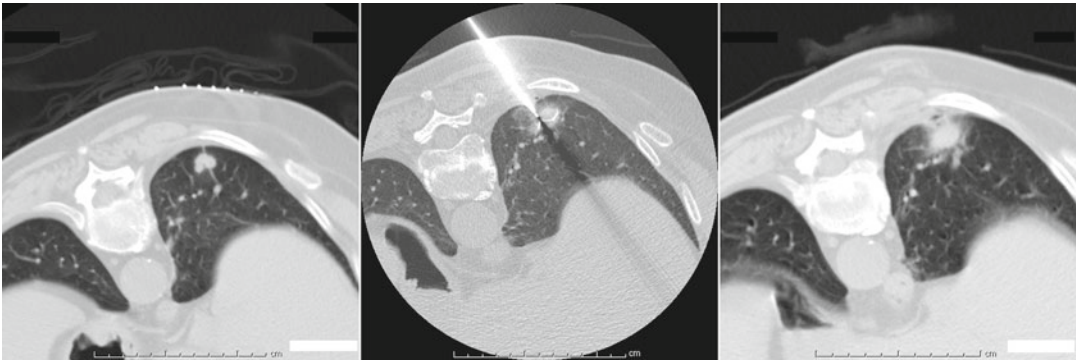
Thermal injury. Prior to radiofrequency ablation (RFA), a biopsy-proven NSCLC is visible in the lower lobe of the right lung (*left*). A multitined needle electrode was placed under CT guidance (*center*). After
